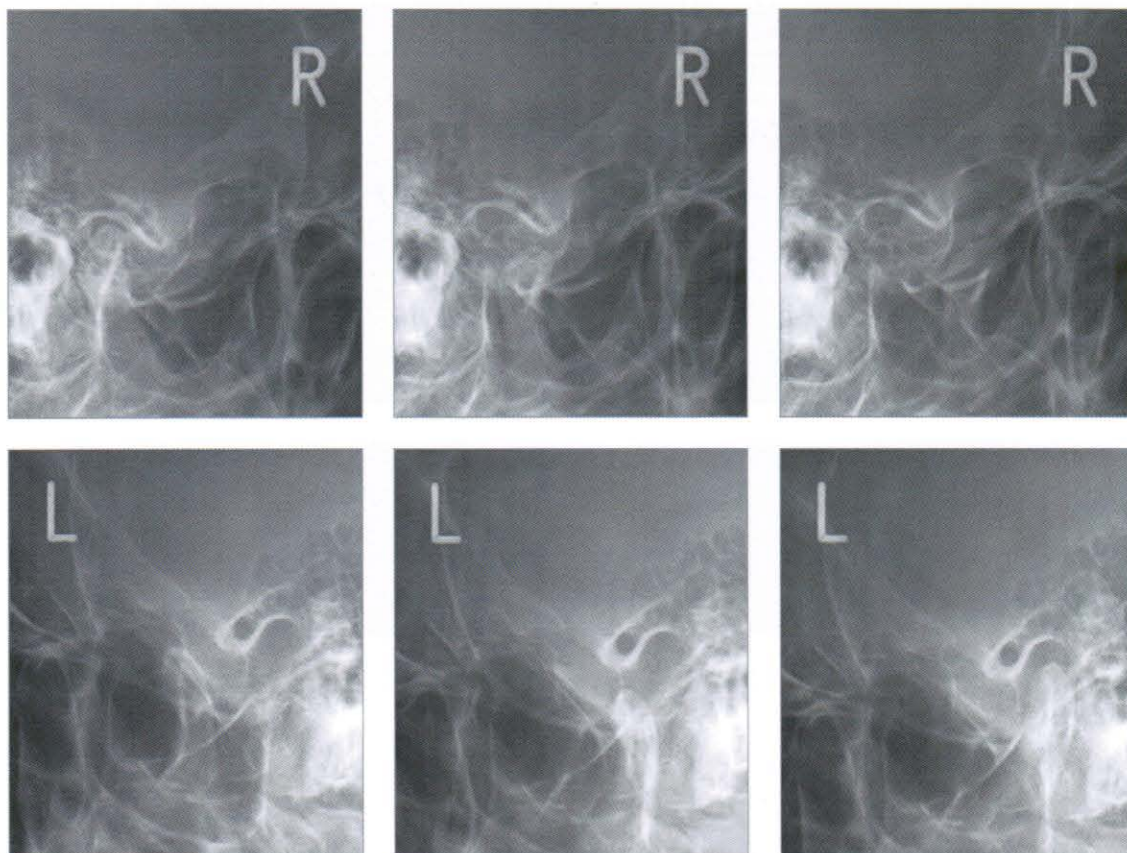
Pre-treatment transcranial radiograph (2006, 9.4)
